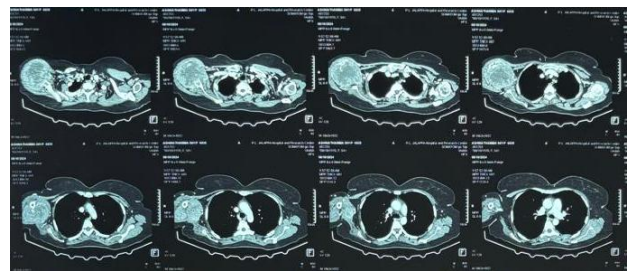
CT thorax showing the expansile lesion of humerus.
